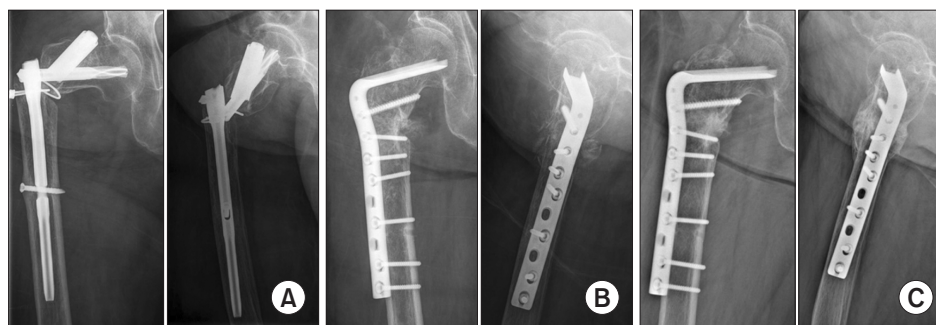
Anteroposterior and lateral plain radiographs of a 79-year-old woman. (A) Preoperative radiographs show breakage of intramedullary nail without any callus. (B) Immediate postoperative radiographs show decorticated bone chip on the outer surface of femoral cortex. (C) Ten-month follow-up radiographs show complete connection of nonunion site with smoothing of decortication surface.
